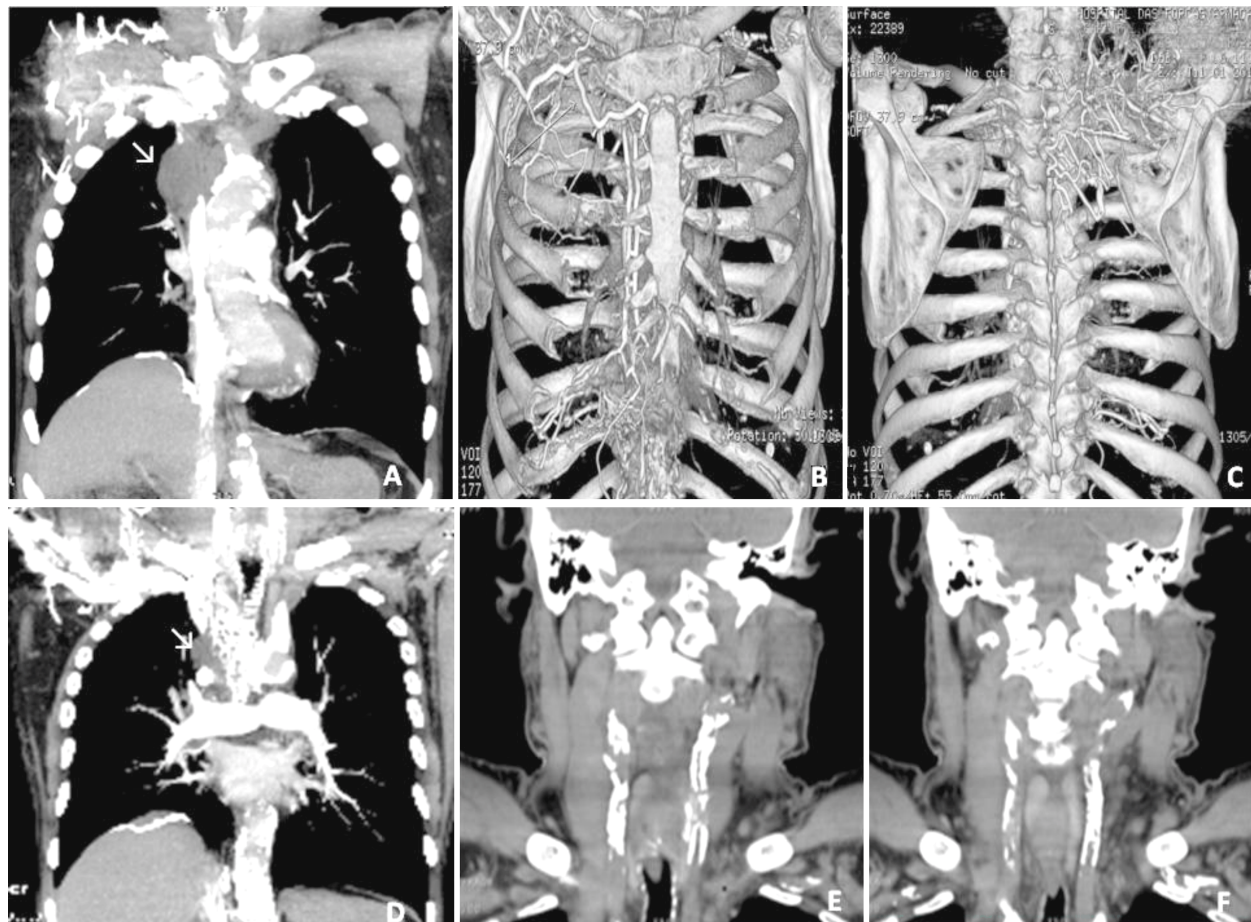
(A) CT images of the oval lobulated mass in the right anterior mediastinum with a density of soft tissue and absence of calcification, involving and occluding the superior vena cava; (B and C) Multiple intercostal collateral veins in the anterior and posterior chest wall; (D and F) Thrombosis of the right internal jugular vein cranially extending to the cervical region. CT: Computed tomography.
